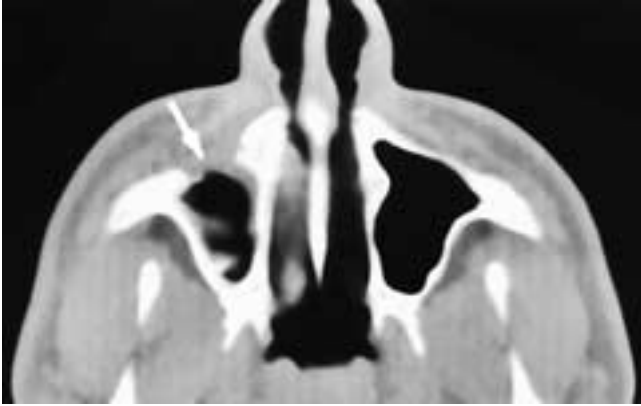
Axial CT scan shows the anterior sinus wall Caldwell-Luc defect (*arrow*). The soft tissues in the sinus were senechia.
